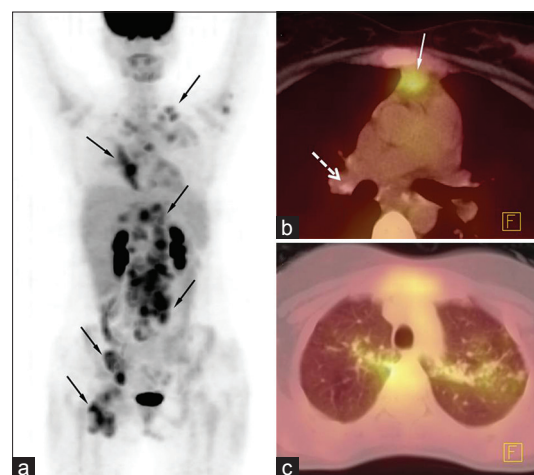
(a-c) A 21-year-old female, known case of tuberculosis. Maximum intensity projection positron emission tomography (PET) image (a) revealed multiple enlarged ¹⁸F-2-fluoro-2-deoxy-glucose (¹⁸F-FDG) avid cervical, axillary, mediastinal, mesenteric, retroperitoneal and inguinal lymph nodes (arrows) transaxial PET/computed tomography (CT) images of thorax (b) ¹⁸F-FDG avid nodal (arrow) involvement. Note the calcification in mediastinal nodes (broken arrow). Transaxial PET/CT image of the lungs (c) ¹⁸F-FDG avid pulmonary involvement
